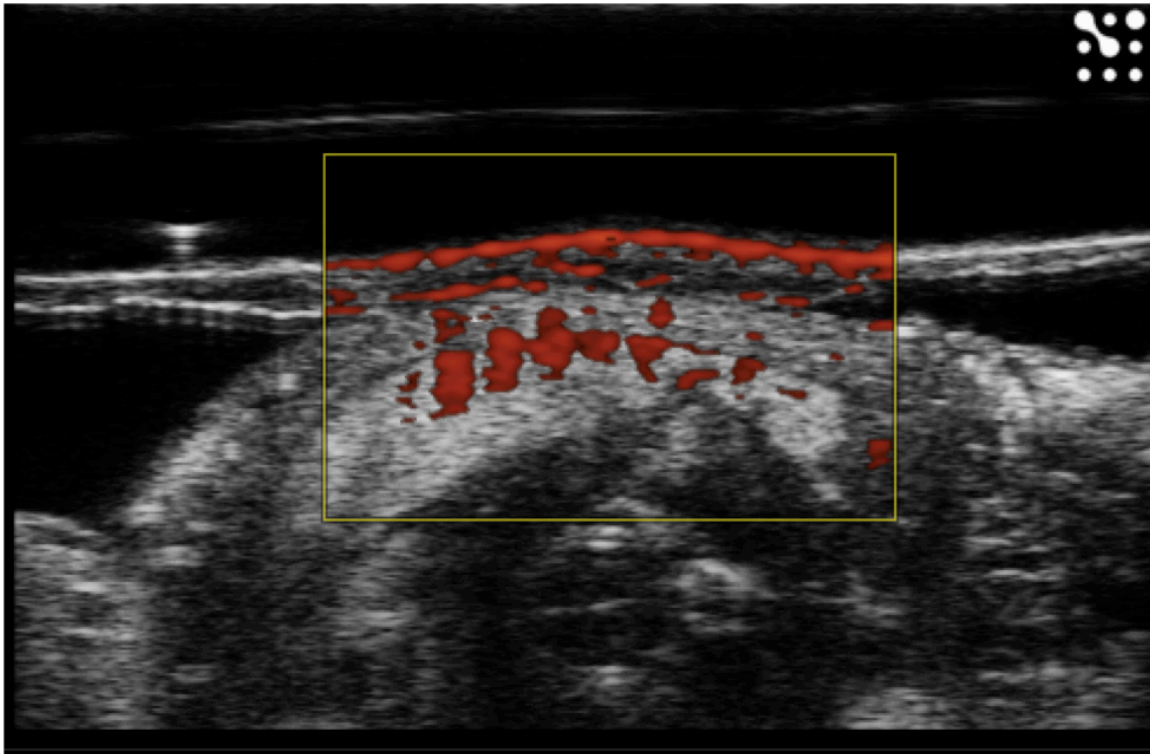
Jail bar artifact in a power Doppler image. Vertical bars of color separated with blank lines are seen overlaying different structures in the image.
